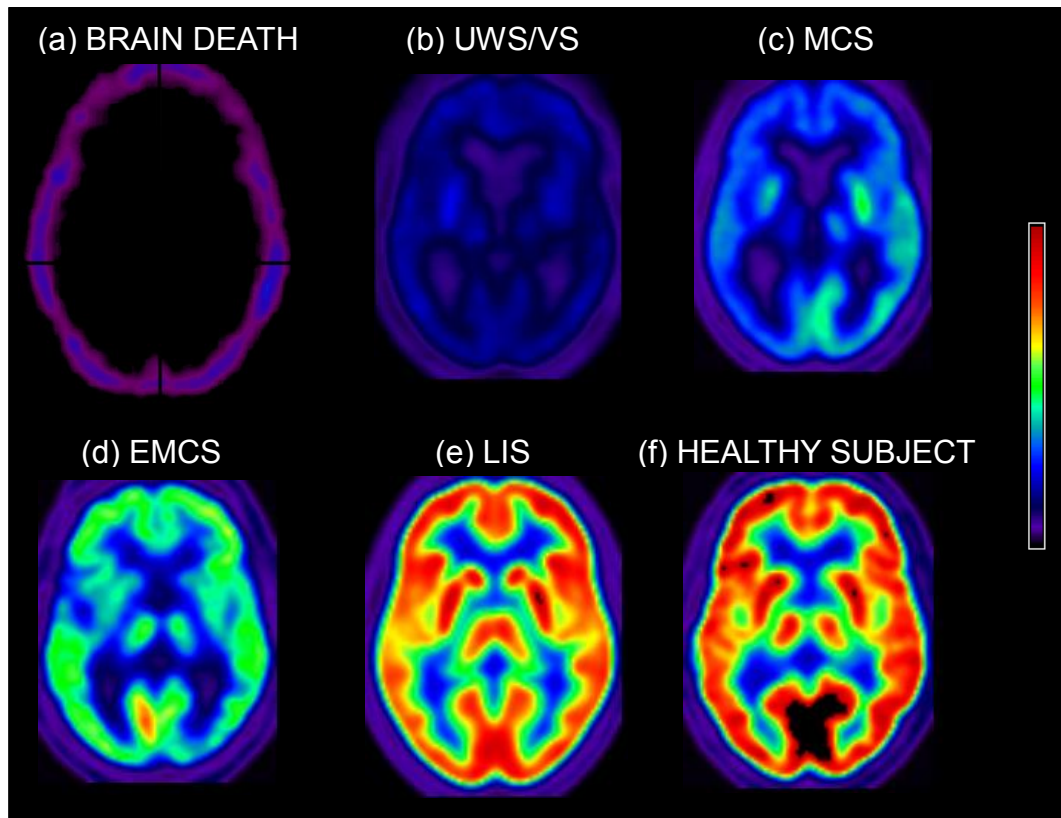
Cerebral brain metabolism acquired with ^{18}F fluorodesoxyglucose-positron emission tomography (FDG-PET) in patients in brain death (a), unresponsive wakefulness syndrome/vegetative state (UWS/VS) (b), minimally conscious state (MCS) (c), emergence of the minimally conscious state (EMCS) (d), locked in syndrome (LIS) (e) and in healthy subjects (f). Adapted from (Laureys, Owen et al. 2004) and (Laureys 2005).
